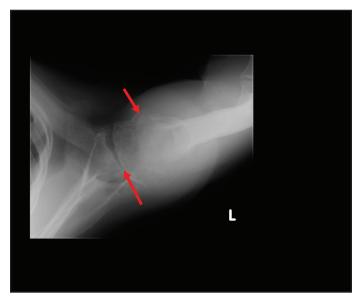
Axillary radiographic view of the left shoulder. The patient shows evidence of a biconcave glenoid with loss of glenohumeral joint space (bottom arrow). An inferior osteophyte is also appreciated (top arrow).
